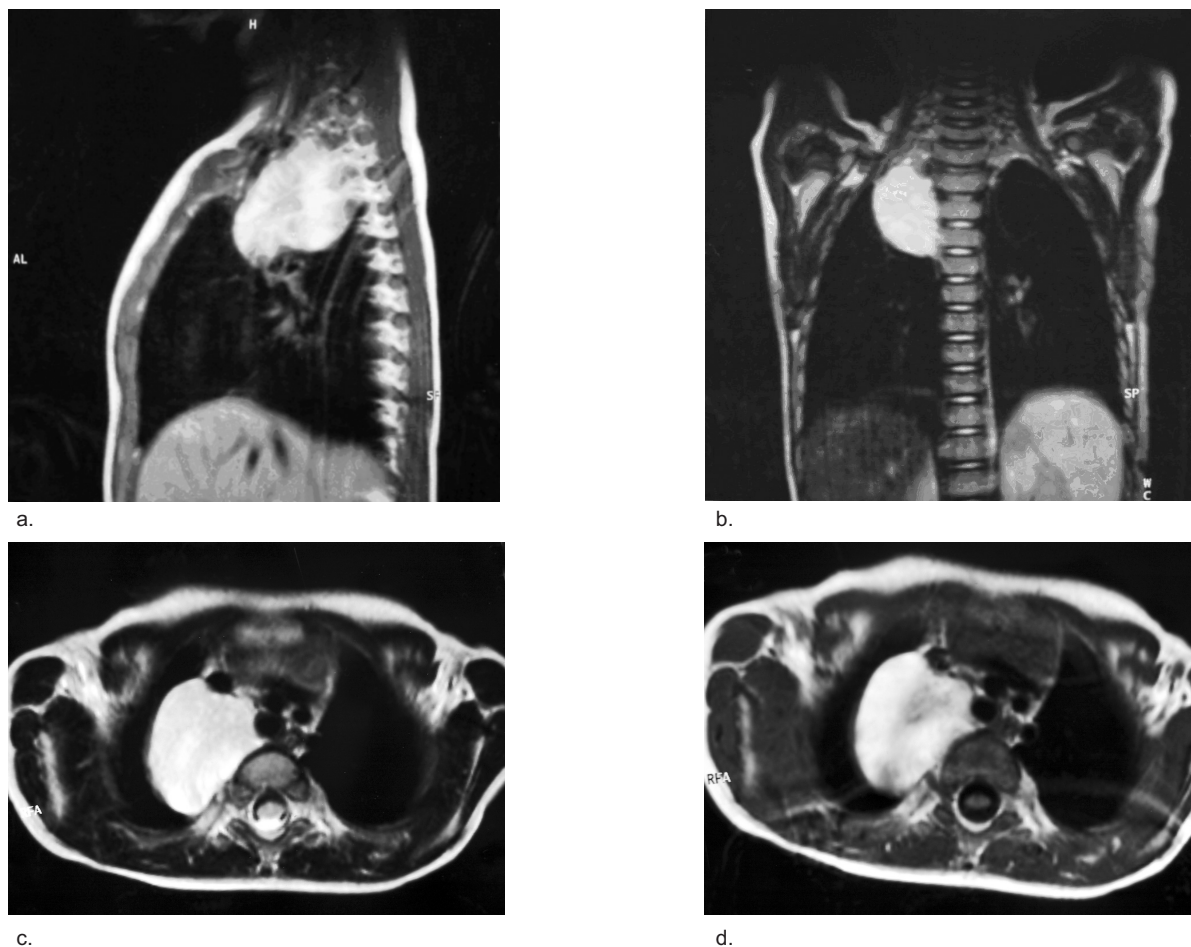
MRI; a, b) Mediastinal mass is shown. c) T2-weighted image. d) T1-weighted image . A high-signal intensity mass on T1 and T2 with a well-defined border is seen.
